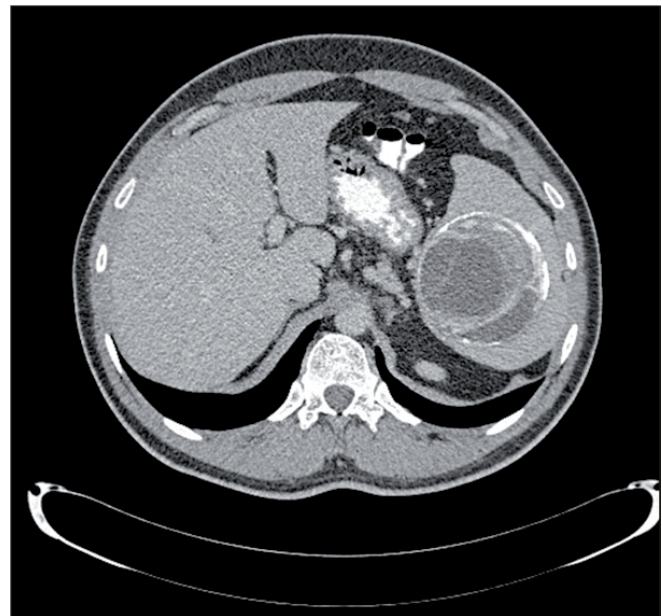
Calcified cystic lesion (84x83 mm) in the splenic parenchyma in abdominal CT.
